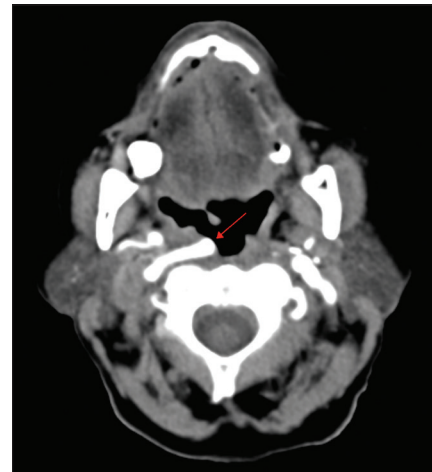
Axial computed tomography angiogram shows the anomaly at the right posterolateral of the pharyngeal wall
